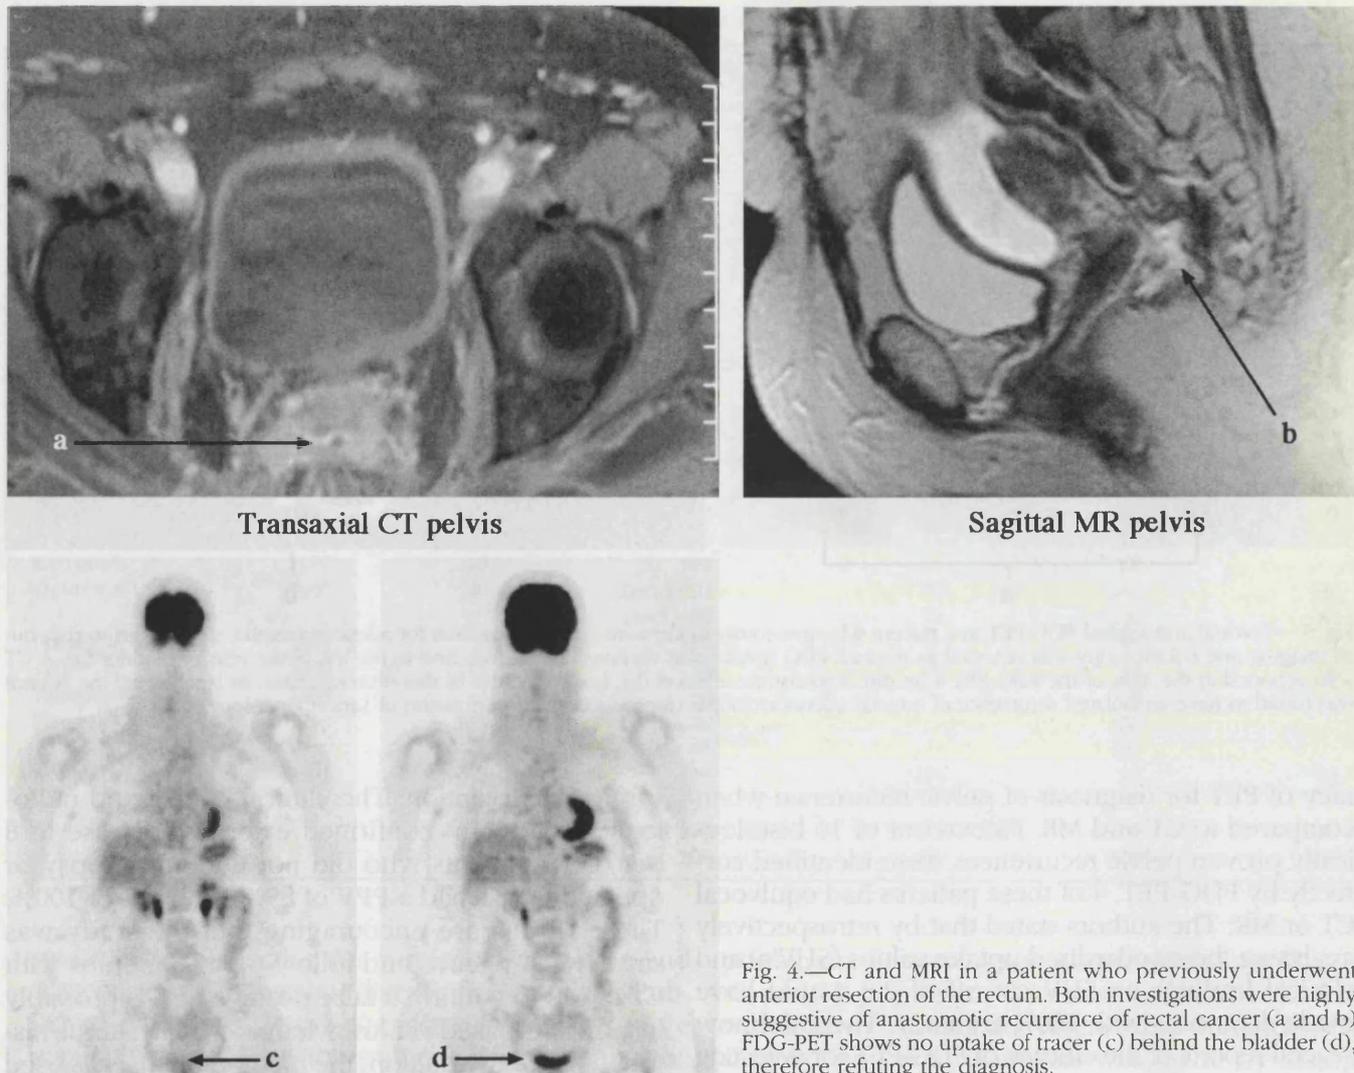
CT and MRI in a patient who previously underwent anterior resection of the rectum. Both investigations were highly suggestive of anastomotic recurrence of rectal cancer (a and b) FDG-PET shows no uptake of tracer (c) behind the bladder (d), therefore refuting the diagnosis.
